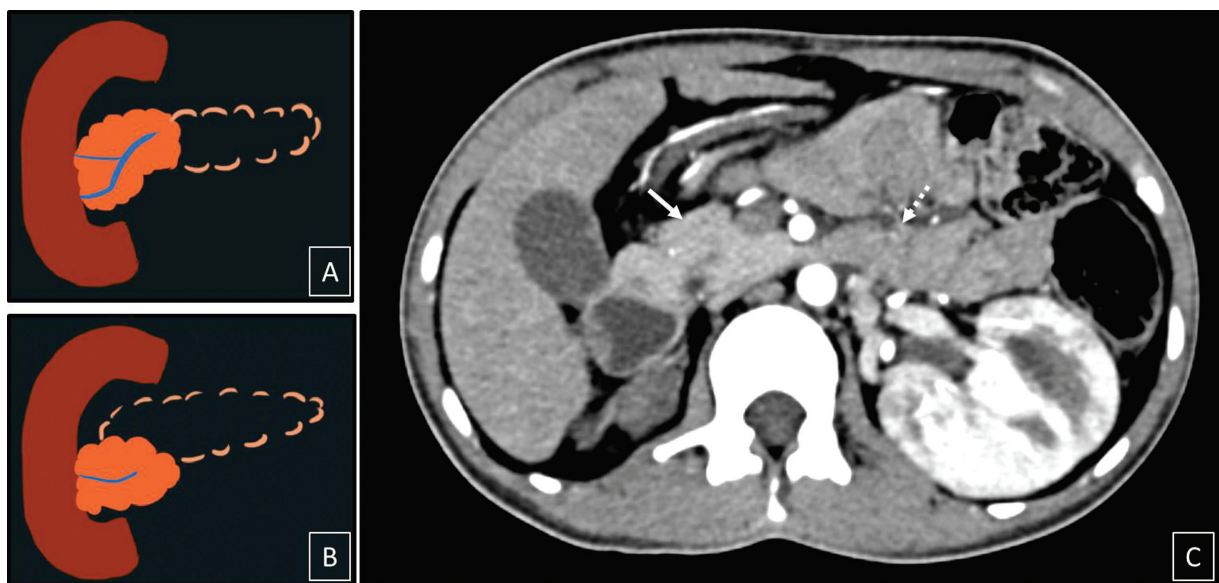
Dorsal pancreatic agenesis. (A) Partial dorsal pancreatic agenesis. (B) Complete agenesis of dorsal pancreas. (C) Axial contrast enhanced CT image showing the presence of head and uncinete process (*arrow*), collapsed jejunal loops (*dashed arrow*) in a case of partial agenesis of dorsal pancreas. No dorsal pancreatic tissue visualized, giving the “dependent intestine” sign.
